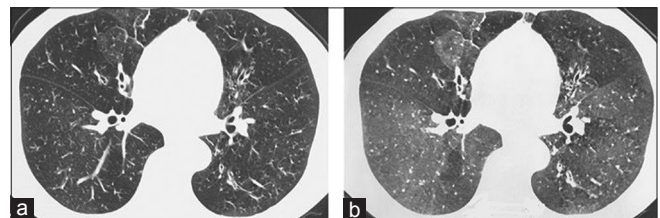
High Resolution Computed Tomography showing the presence of mosaic attenuation in (a) and worsening on expiratory scan in (b)
